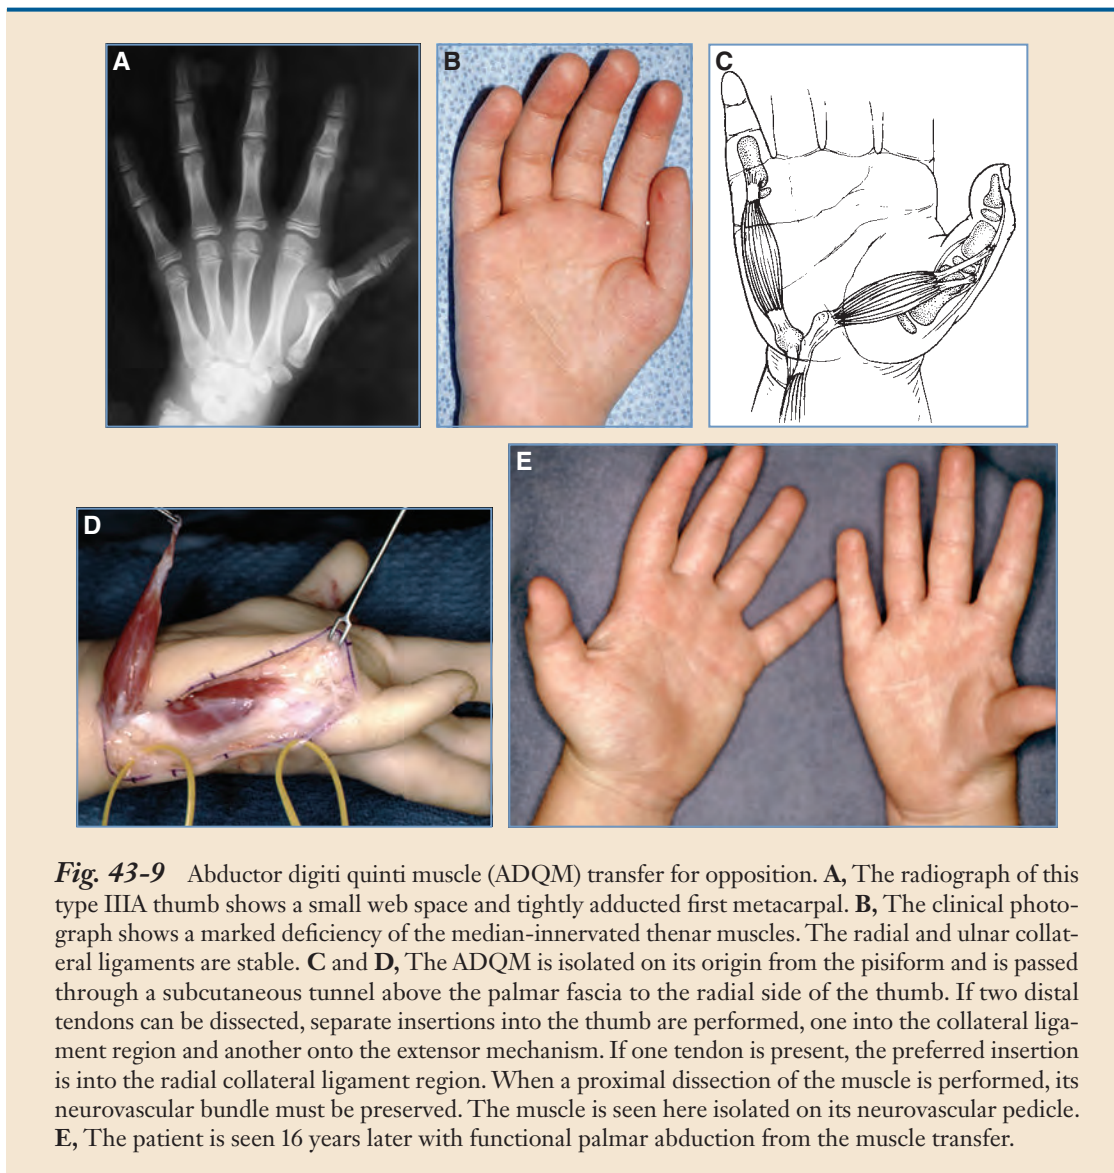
Abductor digiti quinti muscle (ADQM) transfer for opposition. A, The radiograph of this type IIIA thumb shows a small web space and tightly adducted first metacarpal. B, The clinical photograph shows a marked deficiency of the median-innervated thenar muscles. The radial and ulnar collateral ligaments are stable. C and D, The ADQM is isolated on its origin from the pisiform and is passed through a subcutaneous tunnel above the palmar fascia to the radial side of the thumb. If two distal tendons can be dissected, separate insertions into the thumb are performed, one into the collateral ligament region and another onto the extensor mechanism. If one tendon is present, the preferred insertion is into the radial collateral ligament region. When a proximal dissection of the muscle is performed, its neurovascular bundle must be preserved. The muscle is seen here isolated on its neurovascular pedicle. E, The patient is seen 16 years later with functional palmar abduction from the muscle transfer.
